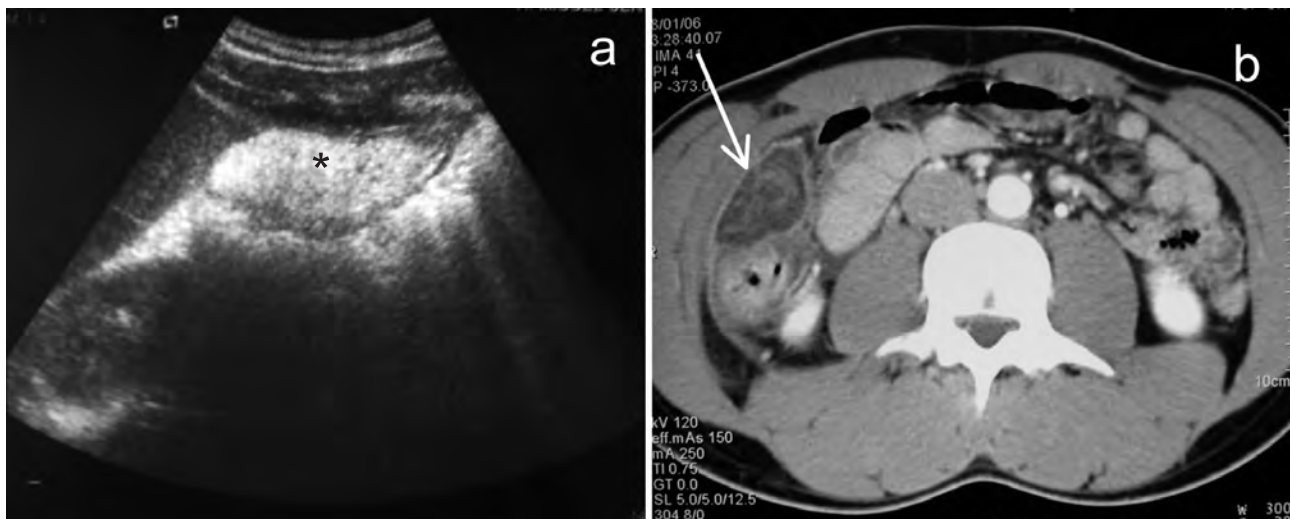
A) Ultrasound image showing a hyperechogenic mass of 6.5 x 6.5 x 2.5 cm in the right flank, with well-defined borders and surrounded by a thin hypoechogenic ring (*). B) Abdominal CT scan showing a mass of fat density (-80UH) located on the serosal surface of the ascending colon (white arrow), surrounded by a hyperdense ring. Within the mass there are irregular areas of high density.
